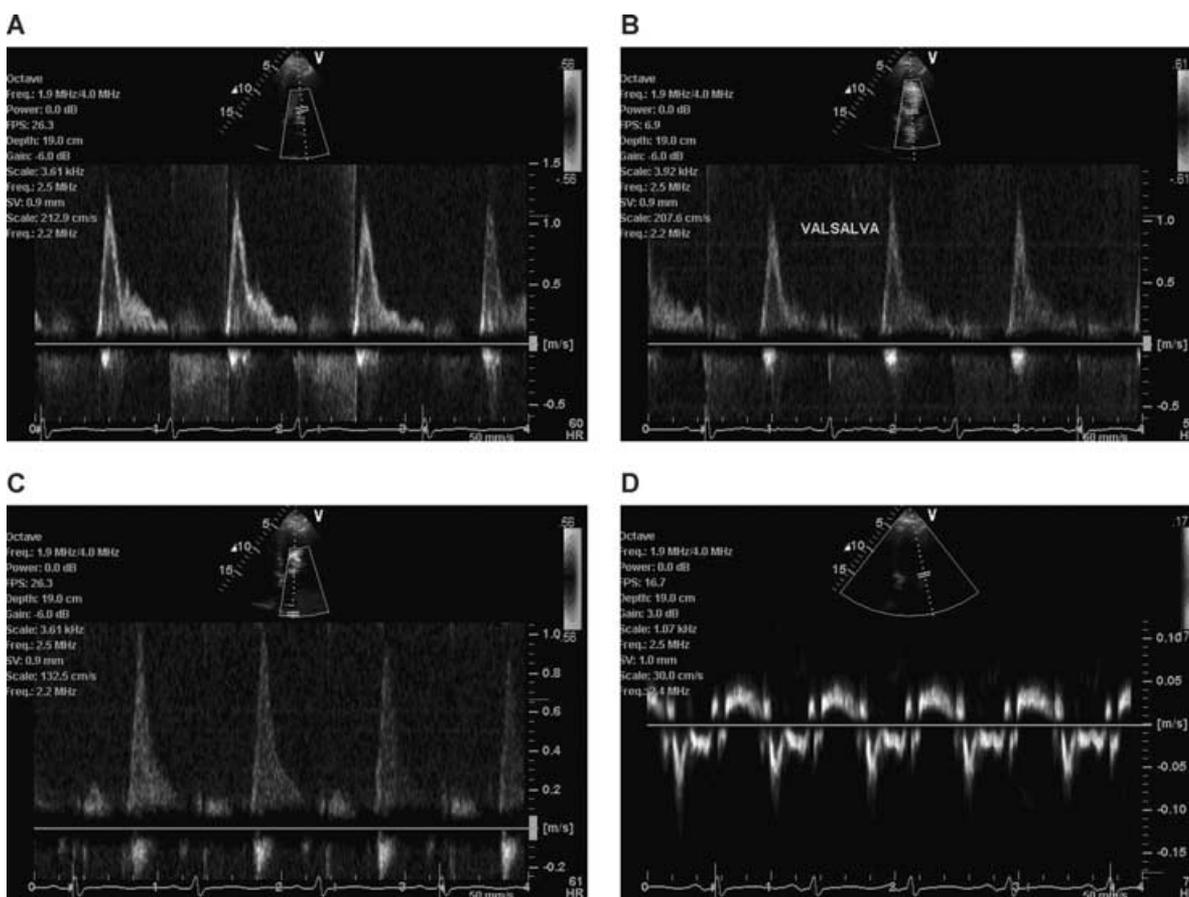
Pulsed-wave spectral Doppler from TTE performed 5 days after RFA showing transmittal inflow during held mid-expiration (A), with Valsalva maneuver (B), left atrial filling (C), and tissue Doppler sampled at the lateral mitral annulus (D). Note the increased E velocity, steep deceleration time of the early ventricular filling, absence of systolic forward flow in the pulmonary vein, and markedly increased diastolic filling velocities in the pulmonary vein. The transmittal inflow pattern does not change with ventricular preload reduction (Valsalva).
